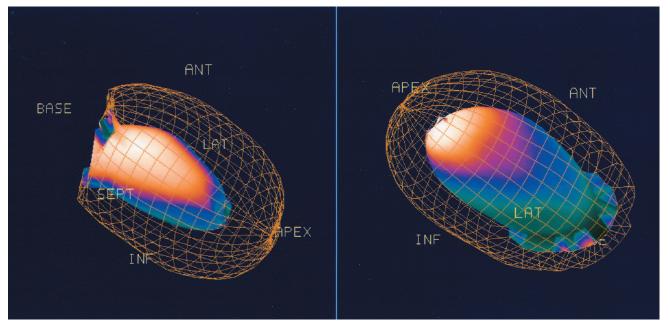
Three-dimensional reconstruction of the left ventricle by single-photon emission computed tomography.
